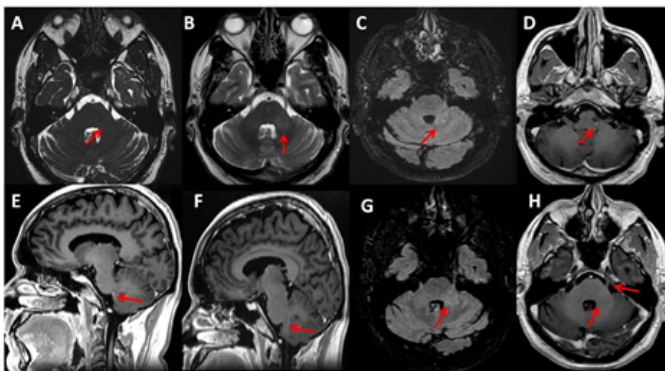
Follow-up MRI after one month (3A-3C) FIESTA and T2 weighted images through the brain show resolving hyperintensity in the left middle cerebellar peduncle (arrow) respectively (3D & 3E) axial and sagittal section of the brain show reduction in the size of the enhancing focus in left inferior cerebellar peduncle (arrow) (3F-3H) Follow-up MRI after 2 months show significant resolution of the left middle and inferior cerebellar peduncle lesions and normal left trigeminal nerve (arrow).
